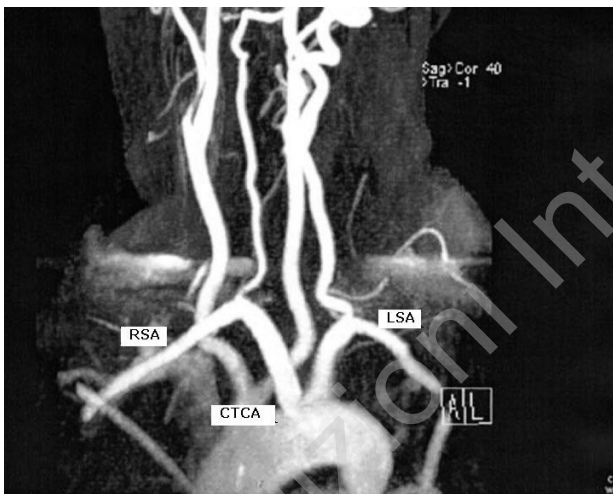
MRI angiogram. Single origin of the common carotid trunk from the aortic arch and concomitant aberrant retro-oesophageal subclavian right artery. RSA: right subclavian artery. CTCA: common trunk of carotid arteries. LSA: left subclavian artery.
